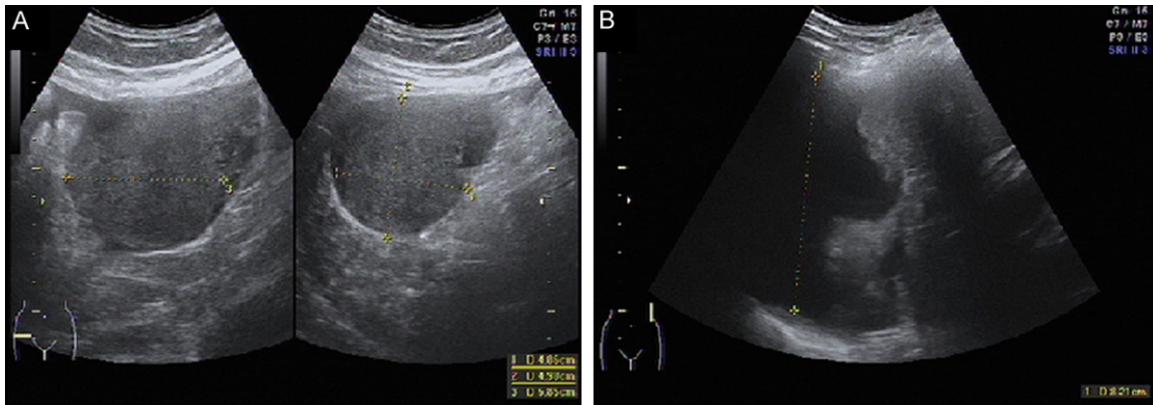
Ultrasound imaging identified a 6×5×5 cm sized right adnexal mass (A). Massive ascites in both abdominal and pelvic cavities (B).
